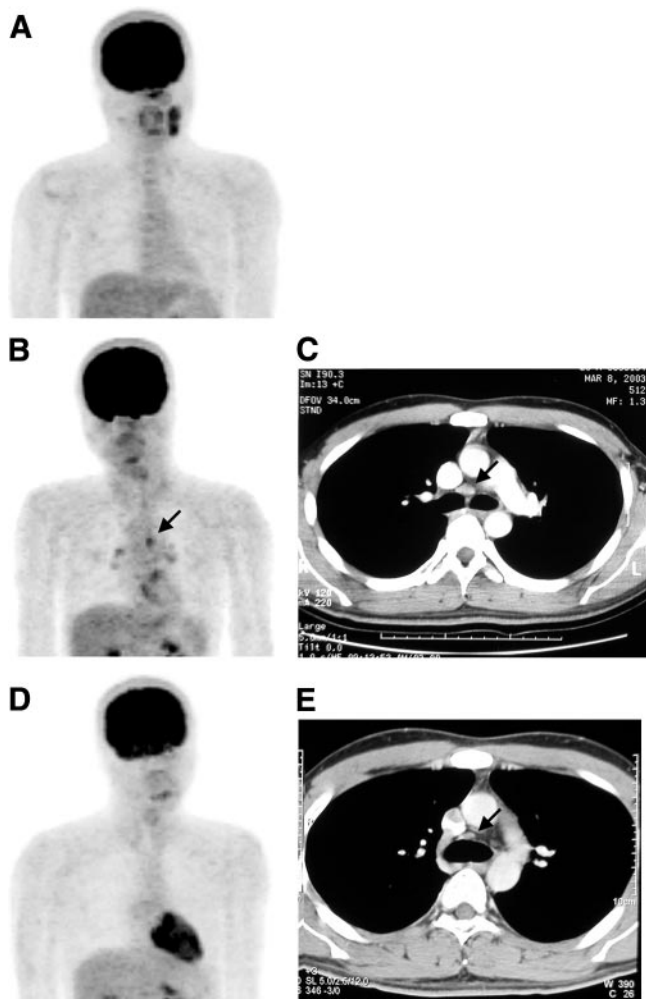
^{18}F -FDG PET and CT scans of 29-y-old male NPC patient (poorly differentiated squamous cell type) with initial clinical stage of T3 N1 M0. Initial ^{18}F -FDG PET scan showed huge tumor in nasopharyngeal roof, with metastases to lymph nodes in left upper and lower neck. No definite evidence of mediastinal lymph node metastasis was noted (A). Three months after definitive concurrent chemoradiotherapy, follow-up ^{18}F -FDG PET showed complete remission of primary and metastatic lesions in left neck. However, equivocal mediastinal lymph node metastatic lesions were noted on both ^{18}F -FDG PET scans and chest CT scans (B and C). Further follow-up ^{18}F -FDG PET scans and chest CT scans showed no evidence of lymphadenopathy in mediastinal region (D and E). Findings shown in B can therefore be considered false-positive after concurrent chemoradiotherapy.
